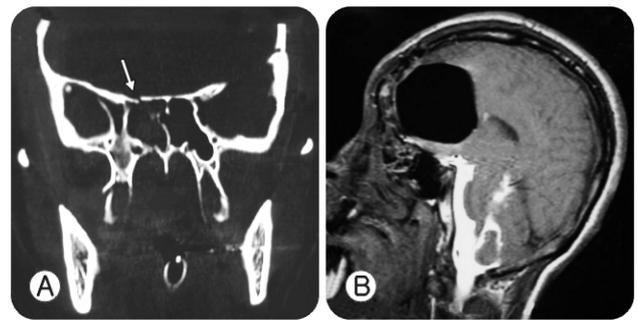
A. Plain CT scan showing opacification of the sphenoid sinus due to trapped CSF with bony dehiscence at the roof of the sphenoid sinus. B. Gd-DTPA MR cisternography showing contrast accumulation at the same site and pneumocephalus.
